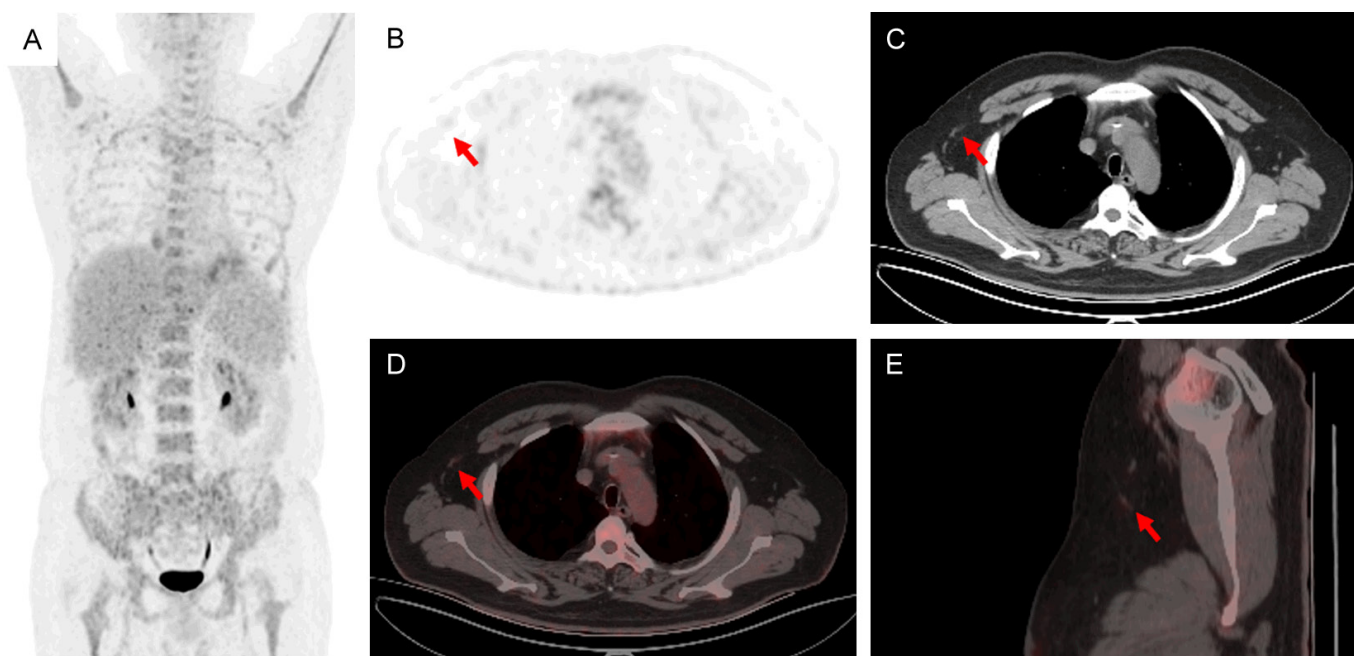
^{18}F -FDG PET/CT images of a patient after treatment for systemic progression of pcALCL. A. After treatment for pcALCL, the whole-body maximum intensity projection showed that most of the multiple areas of high FDG uptake throughout the body have disappeared. B-E. The size and metabolism of the lymph node in the right axilla returned to normal.
